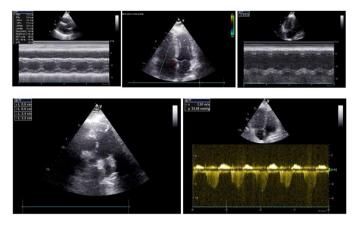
Transthoracic echocardiogram showing the features of acute pulmonary embolism.
